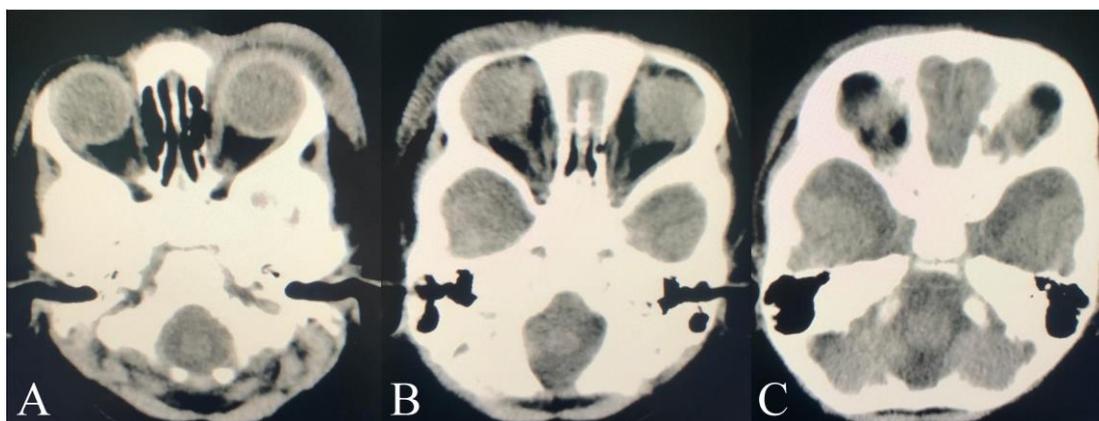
Multiple sections (A-C) of orbital CT-scan without contrast in axial view show preseptal soft tissue swelling in the left eye that infiltrated into the orbit from the medial side.
